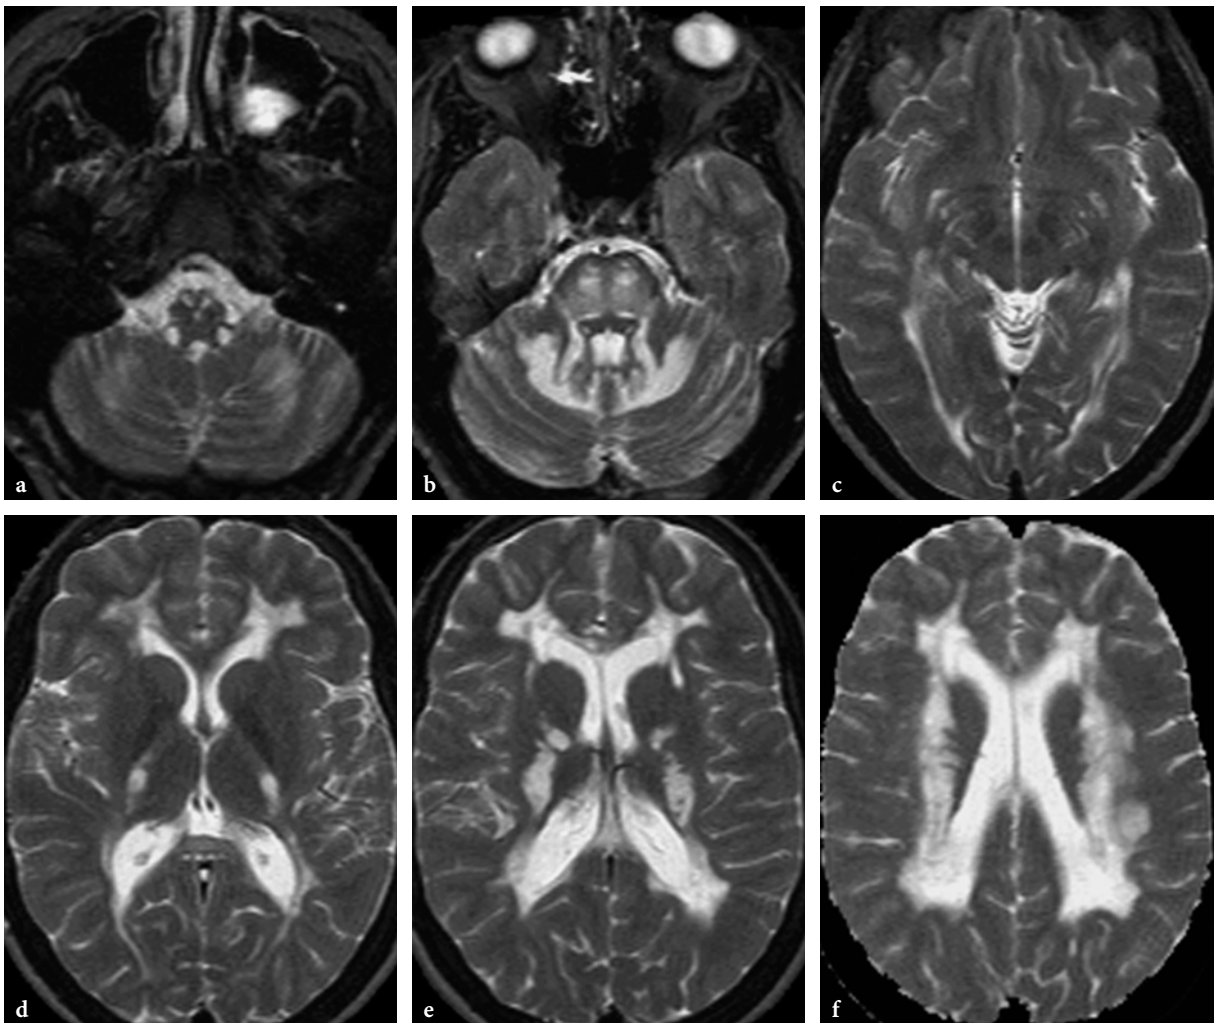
Brain MR imaging findings in a 3.5-year-old female patient with leukodystrophy with brainstem and spinal cord involvement and high lactate on axial T2-weighted fast spin-echo images (courtesy Dr. M. van der Knaap, Amsterdam, The Netherlands). a–f Extensive white matter disease supratentorially (e, f), but the cerebellar white matter is also involved (a, b). Note sparing of the subcortical U-fibers. The posterior limbs of the internal capsules are abnormal (d). At the level of the brainstem (a, b) the signal abnormalities are confined to the pyramidal tracts, medial lemnisci, and intraparenchymal trajectories of the trigeminal nerves
